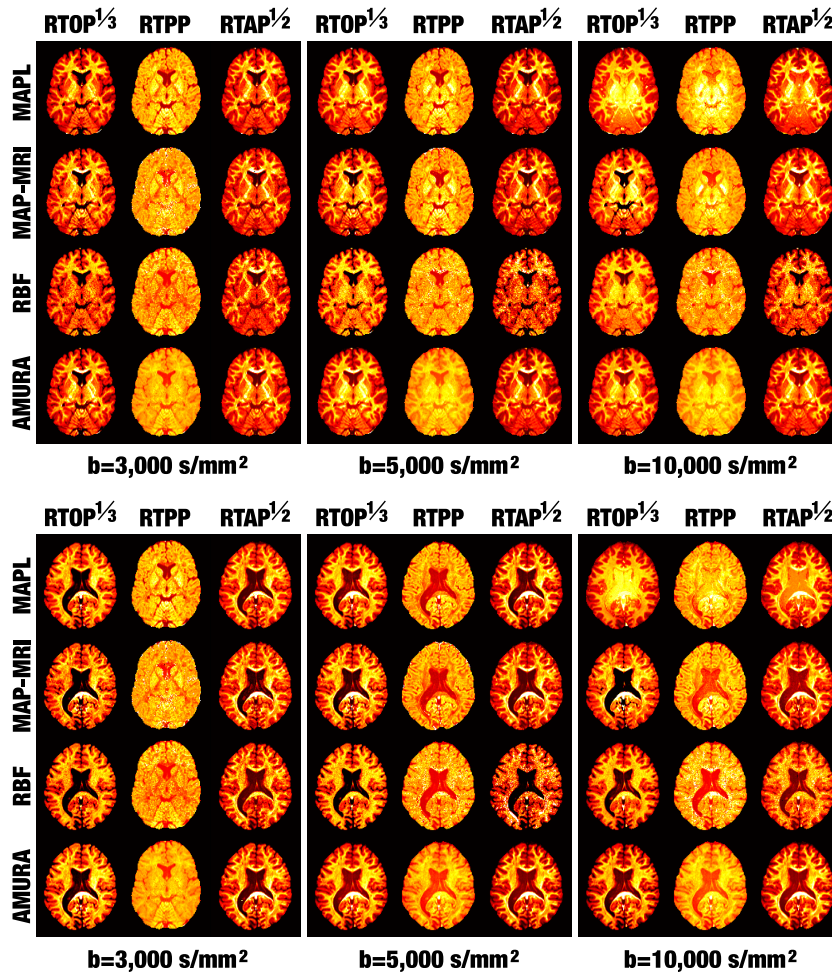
Visual assessment of the consistency of AMURA. (Top) Slice 42 of the MGH1016 volume from HCP; (Bottom) Slice 51 of the MGH1018. AMURA is calculated with one single shell at the specified b-value. MAPL, MAP-MRI and RBF are calculated using either 2 or 3 shells at the maximum b-value specified. For the sake of visual comparison, RTOP and RTAP have been gamma-corrected as specified.
